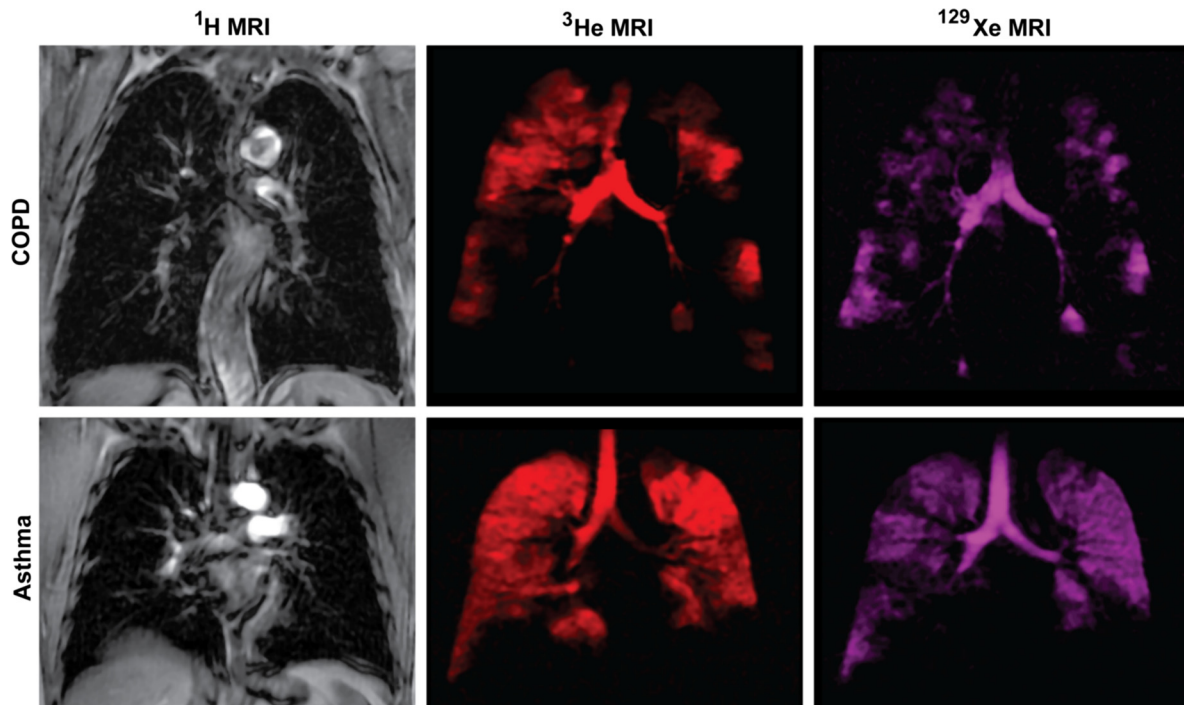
Conventional ^1H -, hyperpolarized ^3He - and ^{129}Xe -MRI of a single subject each with COPD and asthma. ^1H -MRI of the thoracic cavity (gray scale) was obtained in the coronal plane during inspiration breath hold, after inhalation of 1 liter of ultra-high purity N_2 gas from functional residual capacity (FRC). Within 3 min, the same subject inhaled a 1 liter mixture of hyperpolarized ^3He gas mixed with N_2 gas from FRC for static ventilation imaging of ^3He gas distribution (shown in red) acquired in a 15 s breath hold. Approximately 3 min later, the subject inhaled a 1 liter mixture of hyperpolarized ^{129}Xe gas mixed with ^4He from FRC for static ventilation imaging of ^{129}Xe gas distribution (shown in purple) acquired in a 15 s breath hold. Note the qualitative differences in gas distribution abnormalities that are obvious between ^{129}Xe - and ^3He -MRI for both subjects. It is also important to note that the exact etiology of such gas distribution abnormalities has not yet been established. Such differences between ^3He - and ^{129}Xe -MRI gas distribution may be attributable to differences in the gas properties such as diffusion, viscosity, or perhaps tissue solubility.
